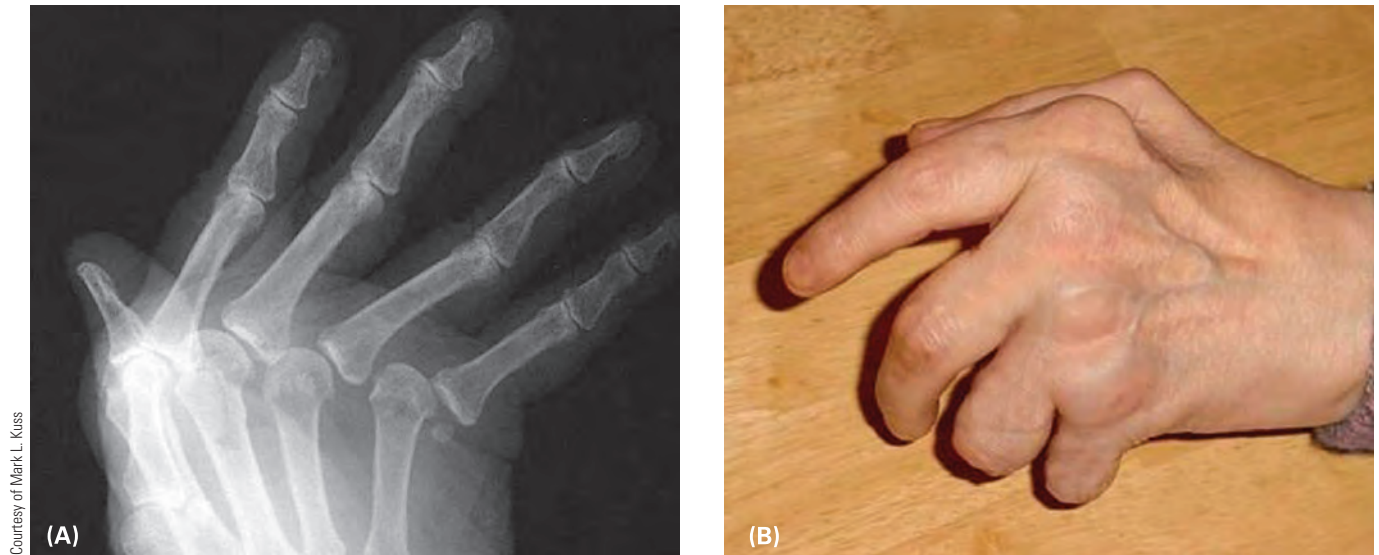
Joint changes from rheumatoid arthritis. (A) X-ray view. (B) Ankylosis.
